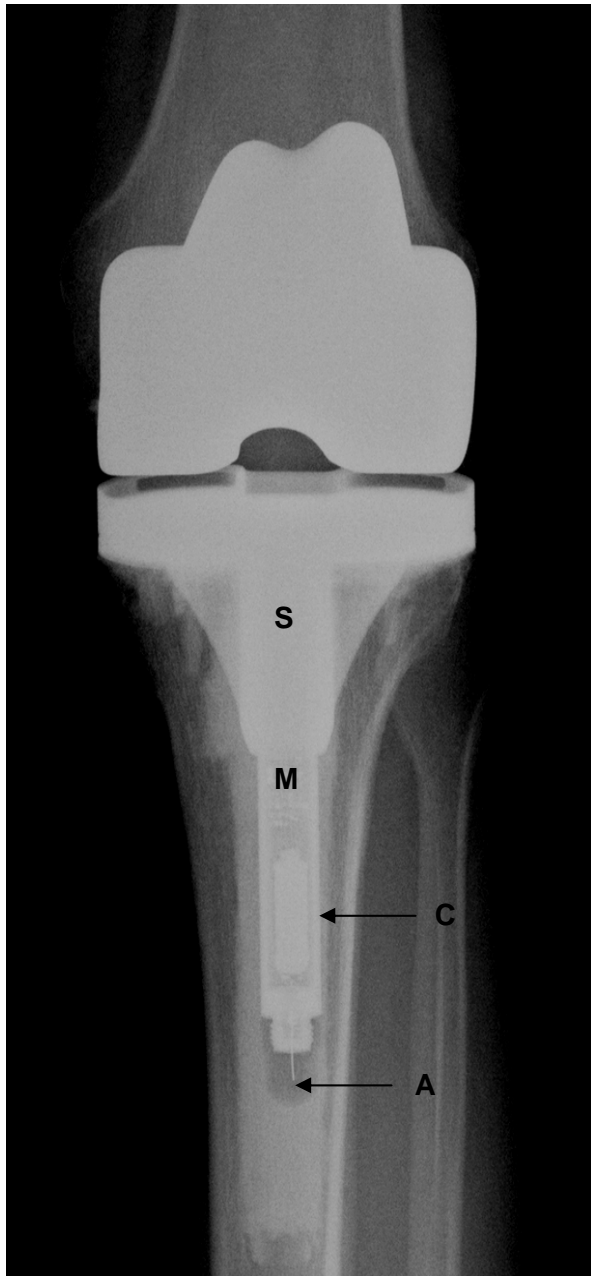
Postoperative radiograph showing the instrumented tibial prosthesis. S: hollow strain-gaged portion of the stem, M: location of microprocessor; C: internal coil; A: transmitting antenna.
